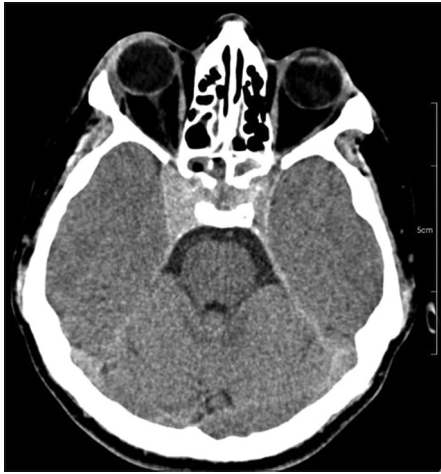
Intra-parasellar formation infiltrating the right cavernous sinus (computed tomography scan)
